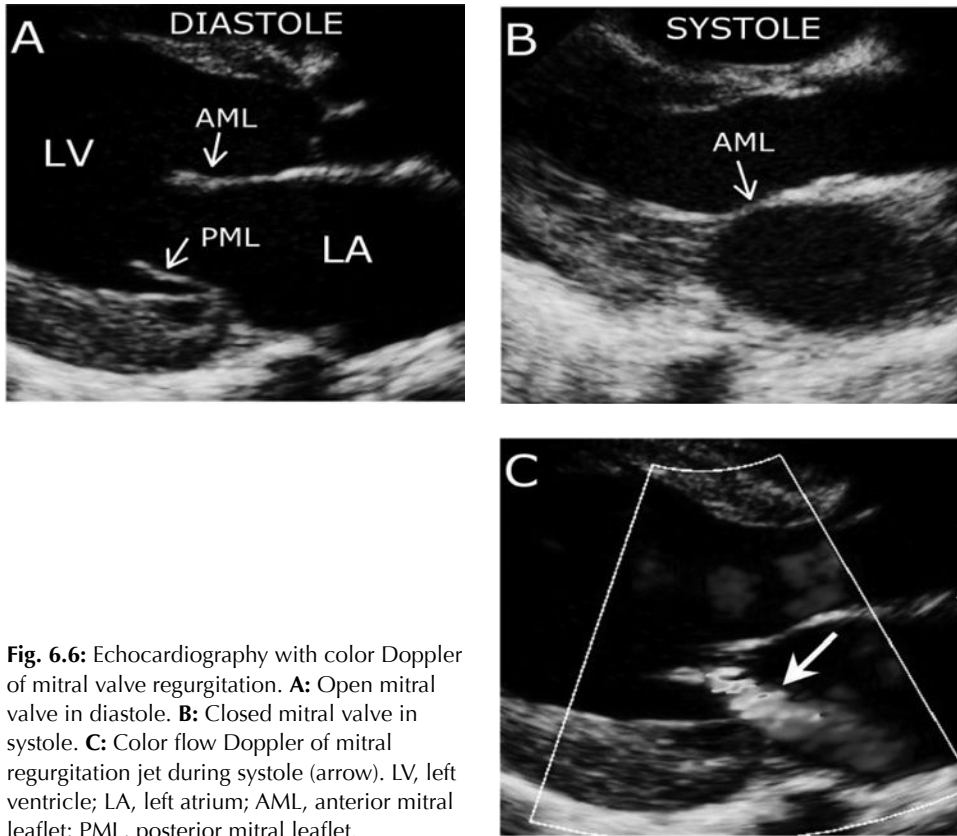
Echocardiography with color Doppler of mitral valve regurgitation. A: Open mitral valve in diastole. B: Closed mitral valve in systole. C: Color flow Doppler of mitral regurgitation jet during systole (arrow). LV, left ventricle; LA, left atrium; AML, anterior mitral leaflet; PML, posterior mitral leaflet.
